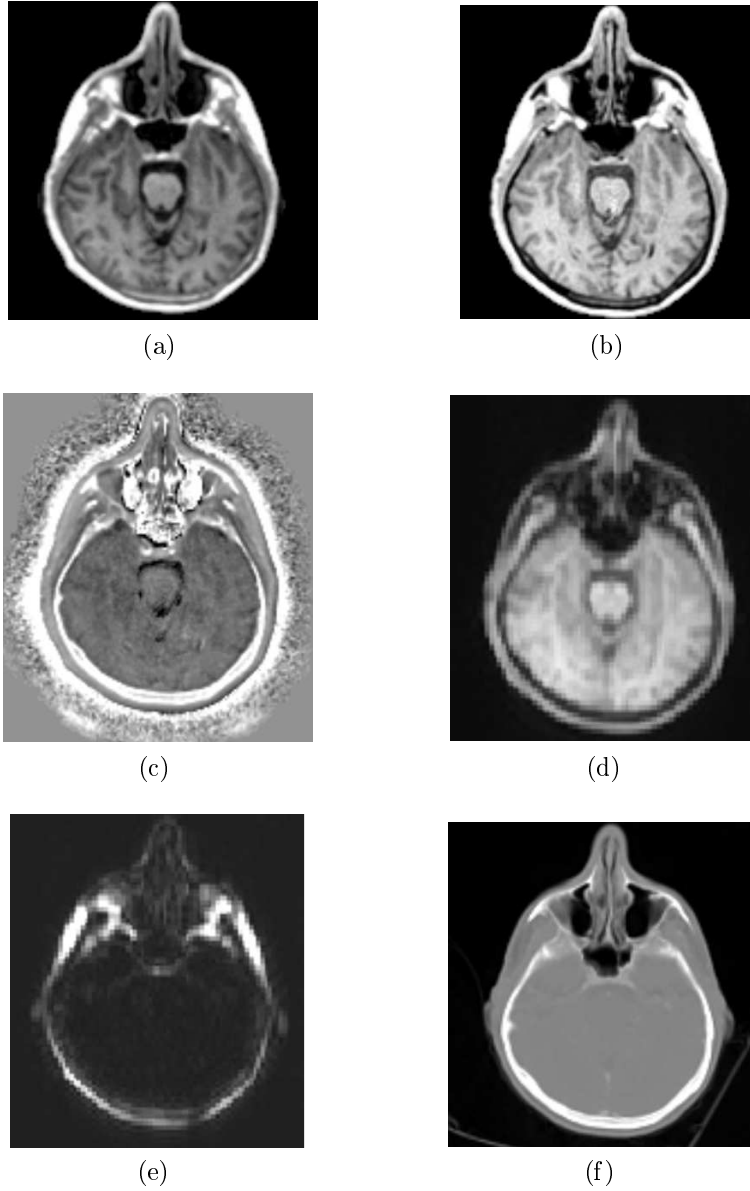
MR sequences and patient CT used for MR-based attenuation correction. (a)  $I_1(x, y, z)$ :UTE-TE1, (b)  $I_2(x, y, z)$ :UTE-TE2, (c) difference image  $S(x, y, z) = \ln I_1(x, y, z) - \ln I_2(x, y, z)$ . (d) 3-D Dixon-water, (e) 3-D Dixon-fat. Note that the cortical bone is clearly visible in (c) as compared to (d) or (e). (f) Patient CT.
